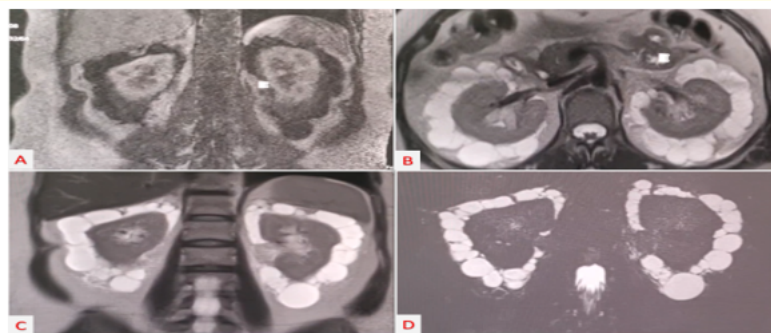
MRI imaging: (A) T1 coronal, (B) T2 axial (C) T2 coronal (D) T2 HASTE coronal, showing multiple cystic lesions involving the perinephric region. These lesions demonstrate low signal intensity on T1-weighted images and high signal intensity on T2-weighted images, consistent with fluid content with thin internal septations.
